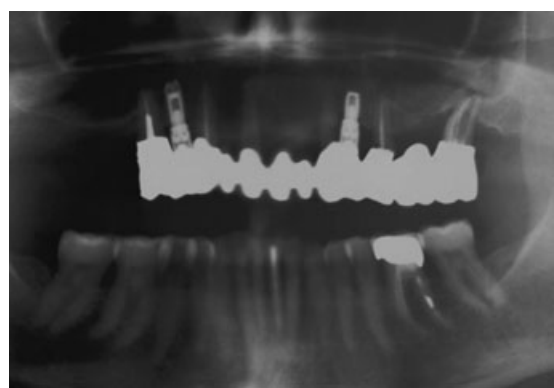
Preoperative panoramic radiograph of the patient in Figure 4. The metal ceramic prosthesis was supported by endodontically treated teeth and two implants.
